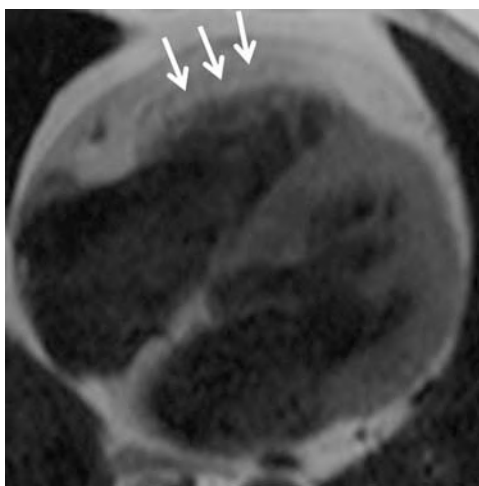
Non-ARVC/D fat infiltration in the RV wall on CMR. Axial dark blood T1-weighted CMR images in a 70-year-old man being evaluated for palpitations. There is marked thickening of the wall of the RV secondary to fat infiltration (arrows). This degree of thickening is not typically seen for ARVC/D, which is associated with wall thinning and myocyte replacement.
